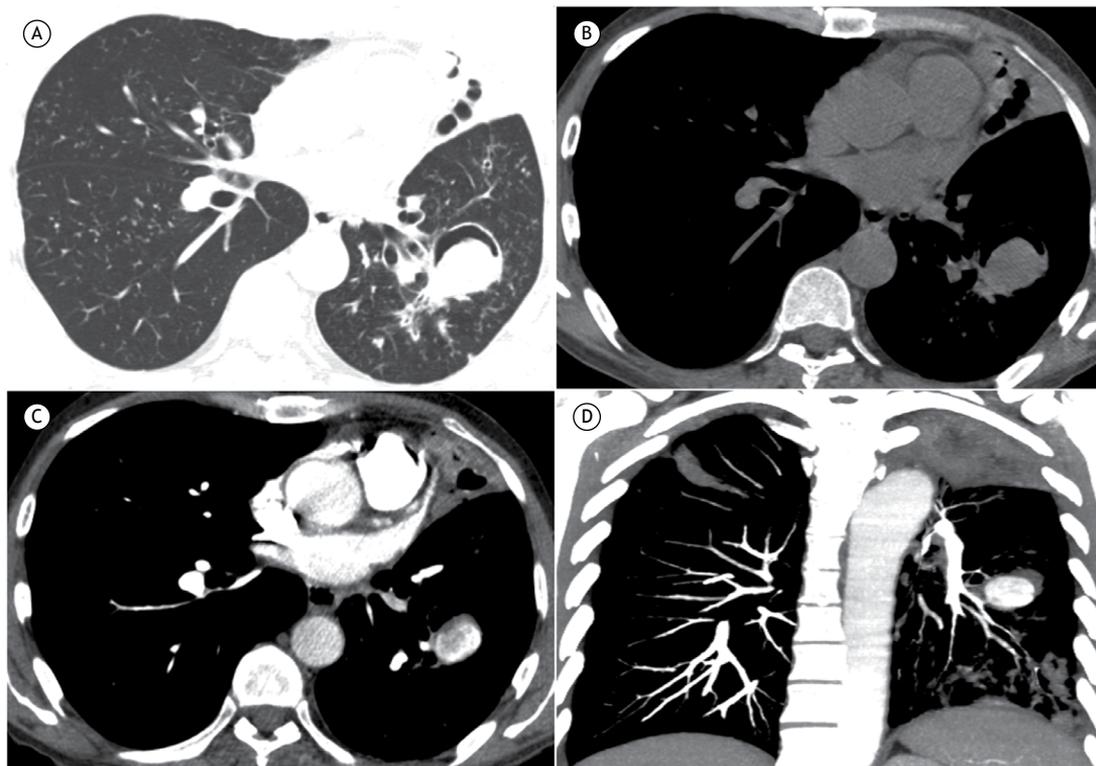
In A, an axial CT scan with a lung-window setting at the level of the lower lobes, showing small nodules in both lungs, a consolidation with cavitation in the lingula, and a nodule inside a cavity, with air interposed between the nodule and the cavity wall (the air crescent sign). In B, an axial CT scan with a mediastinal-window setting, demonstrating that the nodule is homogeneous. In C and D, axial and coronal reconstructions, respectively, of contrast-enhanced CT scans, showing intense enhancement of the intracavitary nodule.
